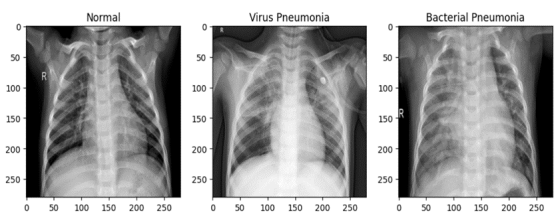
X-ray image of pneumonia
